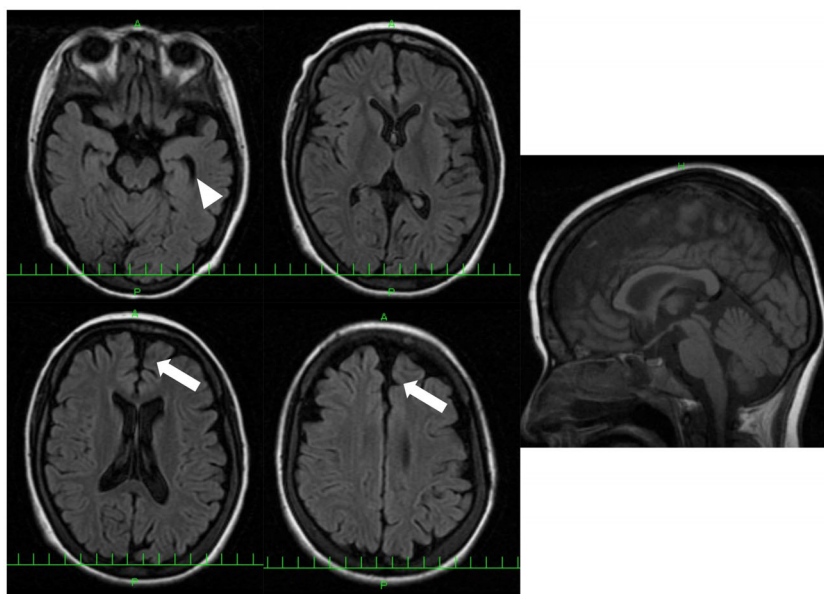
Brain MRI of patient 7 with p.Tyr679Ser variant. FLAIR images show frontal (arrow) and temporal lobe atrophy (arrow head). White matter change and corpus callosum change are not observed.
